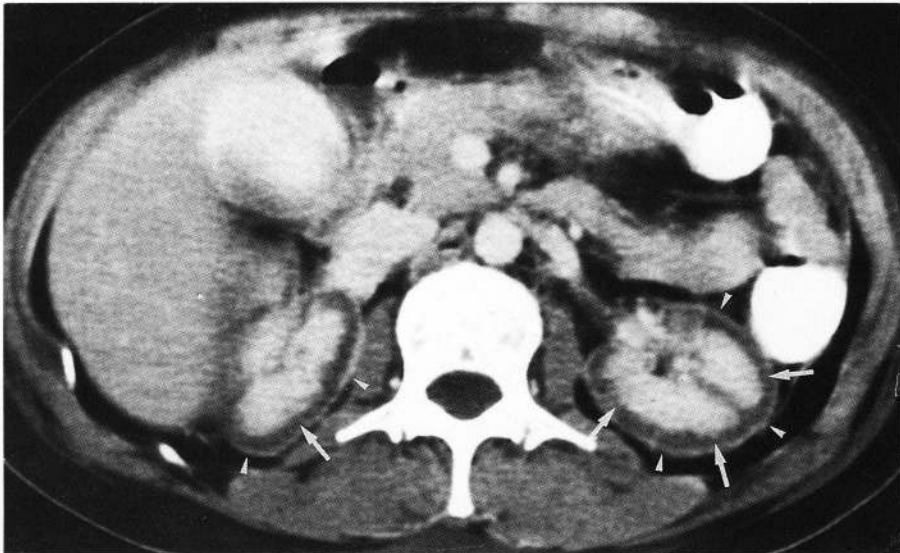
Contrast-enhanced CT scan of day 2 in hospital course showing the characteristic and specific findings of bilateral renal cortical necrosis (BRCN). Note the lack of enhancement of the cortex (white arrows) with preserved enhancement of a thin rim of the subcapsular area (white arrow heads) and medulla. There is no excretion of contrast media from both kidneys and the vicarious excretion of contrast media was noted in the hyperdense gall bladder.
